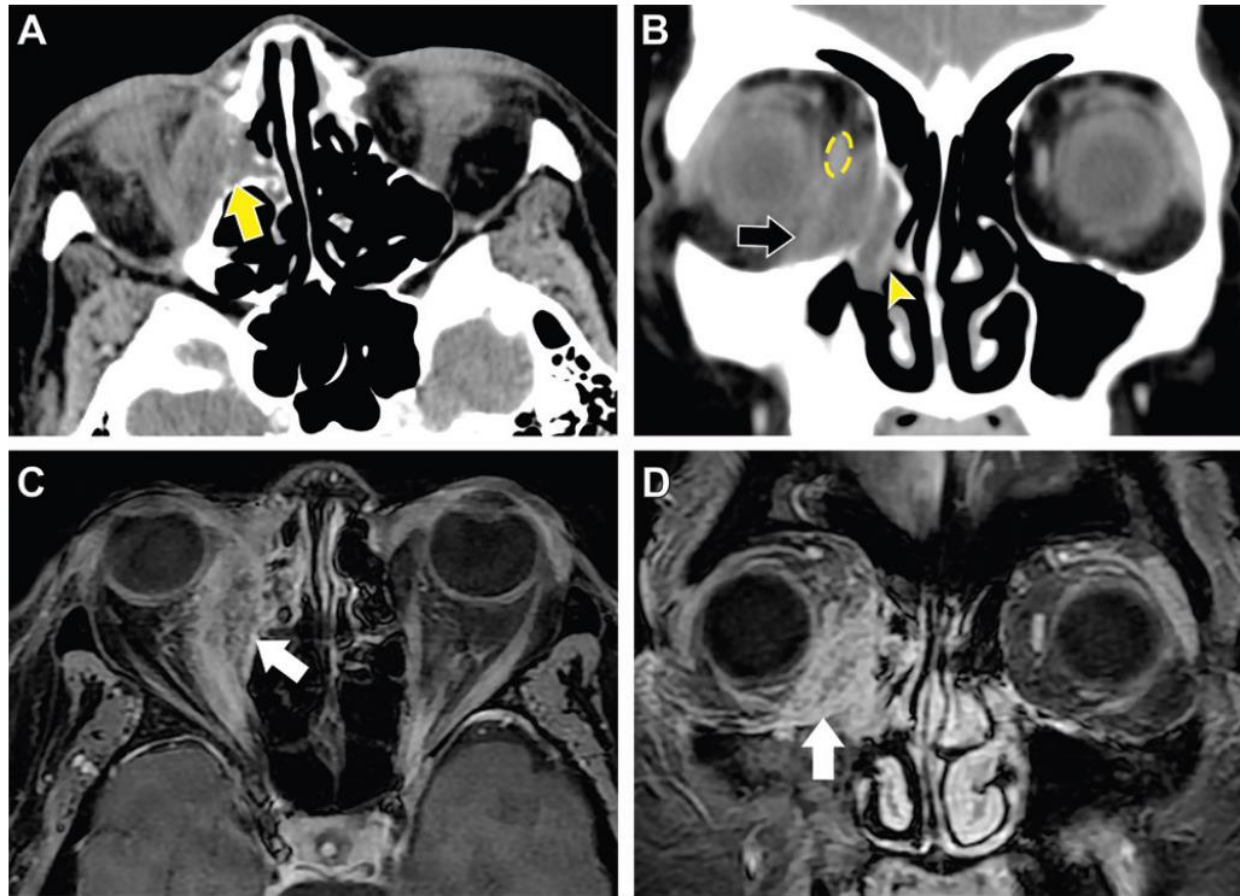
Orbital pseudotumor in a 51-year-old woman. (A, B) Axial (A) and coronal (B) contrast-enhanced CT images show a right orbital soft-tissue lesion with papyraceous lamina destruction (arrow) and obliteration of the middle meatus (arrowhead in B). Note the superior displacement of the medial rectus muscle (dashed oval in B). (C, D) Corresponding axial (C) and coronal (D) gadolinium-enhanced MR images better depict intense enhancement (arrow).
